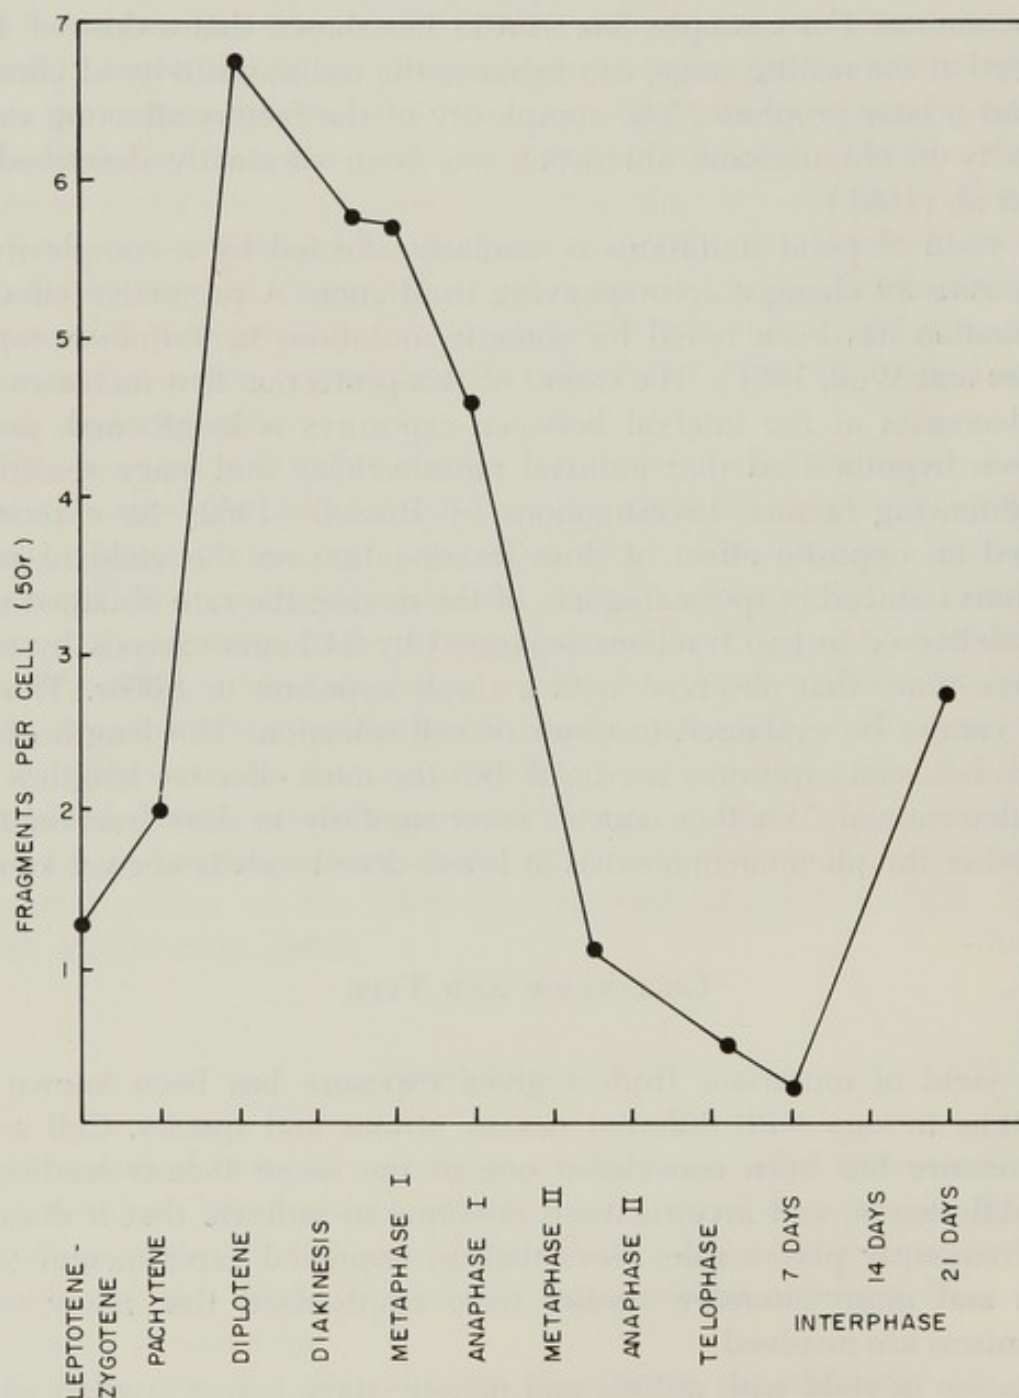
Sensitivity to the induction of chromosome breaks by x-rays in different stages of cell division (from Sparrow, 1951).
